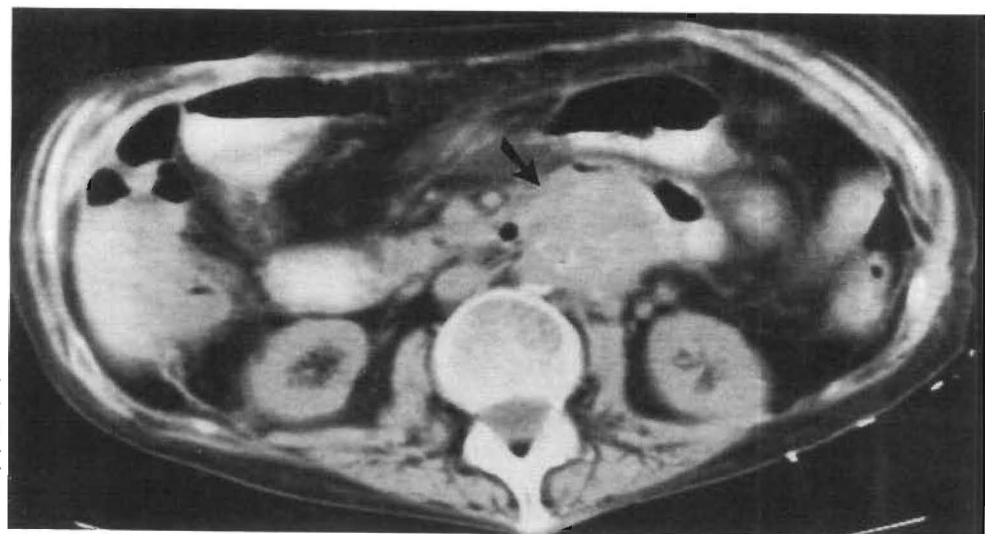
Large pseudoaneurysm (arrow) of the proximal anastomosis of an iliac artery homograft demonstrated on abdominal CT scan.
